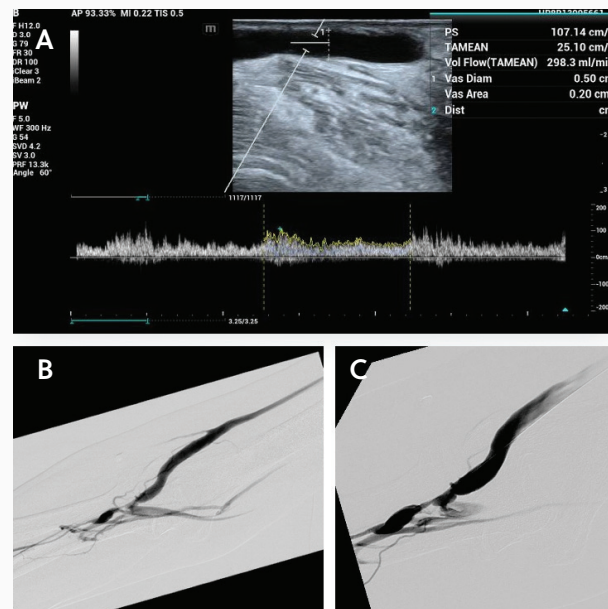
Duplex ultrasound flow volume measurement of the cephalic vein (A). A transradial AV fistulogram showed a high-grade, short-segment stenosis (B, C)
